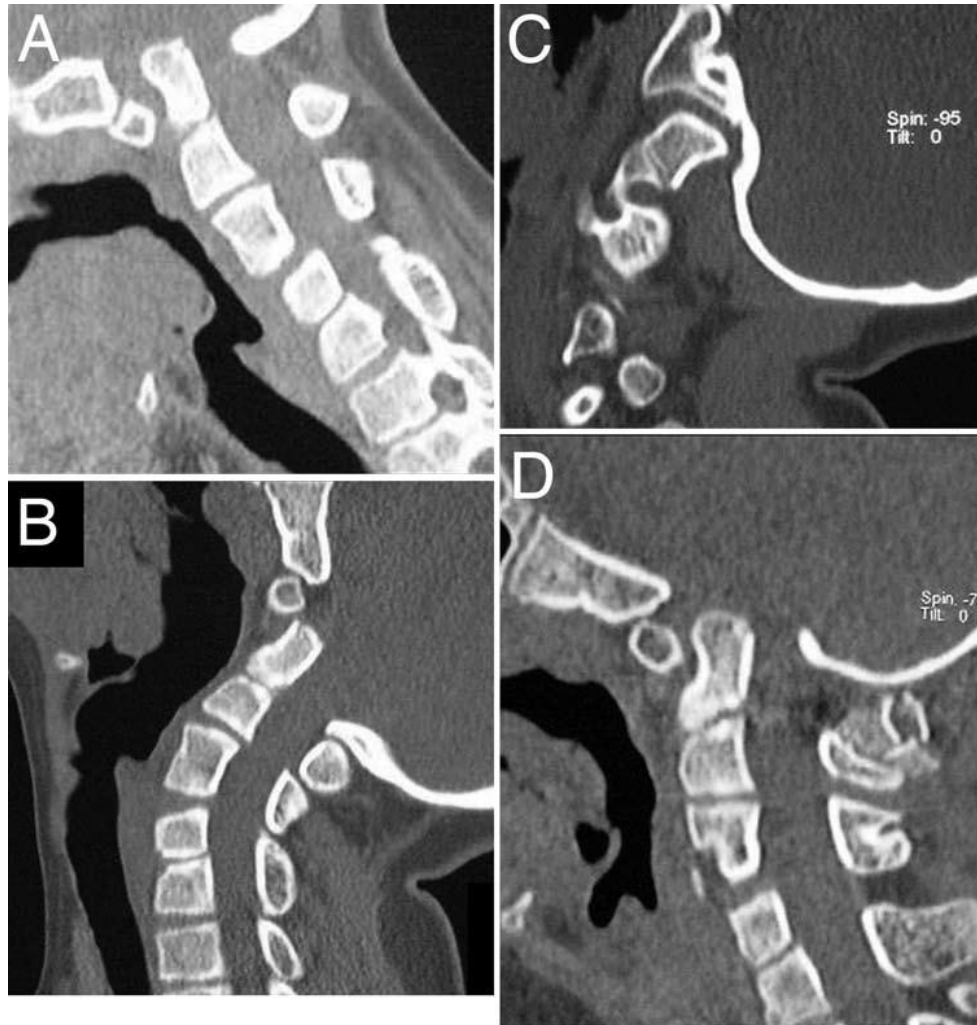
Neuroimages obtained in a 12-year-old boy with unstable basilar invagination. A: Sagittal CT scan with the head in flexion, showing the presence of basilar invagination. B: A CT scan with the head in extension position showing reduction of the basilar invagination. C: A CT scan with the cut traversing the atlantoaxial joint. An abnormal configuration of the joint can be appreciated. D: Postoperative CT scan showing fixation in a partially reduced position.
